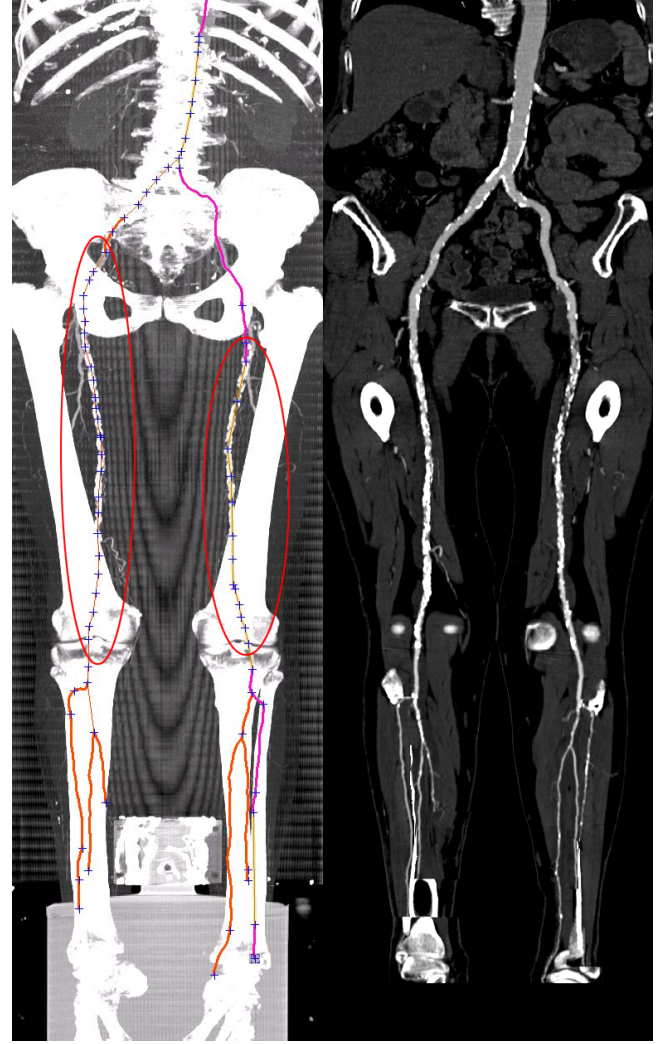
MIP image (left) of a clinical peripheral CTA dataset obtained in a patient with advanced peripheral arterial disease with superimposed tree of vessel-centerlines. The encircled areas indicate vessel regions, where automated centerline calculations failed due to excessive disease and vessel calcifications, and thus required manual placement of center points by a radiologist, to achieve the resulting Curved Planar Reformation (right).
